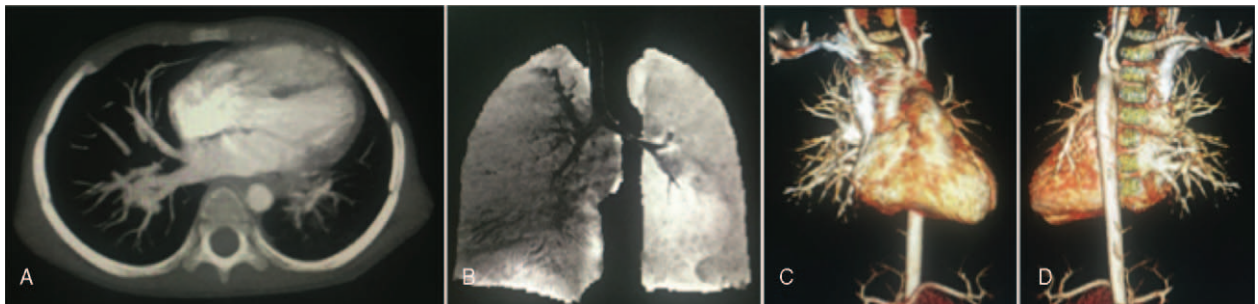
Chest CT scan showed a smaller caliber of the left main pulmonary artery and ipsilateral vessels compared with the right (A); chest CT with 3D reconstruction revealed the left lung parenchyma with slight hypoplasia like mesenchyme (B); chest CTA with 3D reconstruction showed that the left main pulmonary artery and ipsilateral vessels were smaller in caliber in comparison with the right, and bilateral bronchial artery was circuitous and thickening, particularly the left bronchial artery more apparent. Besides, there were no left pulmonary veins draining into the left atrium visualized on the images. The margin of the left atrium in the expected location of the left pulmonary vein was entirely smooth, without evidence of vascular structures connected to it (C, D). CT = computed tomography.
